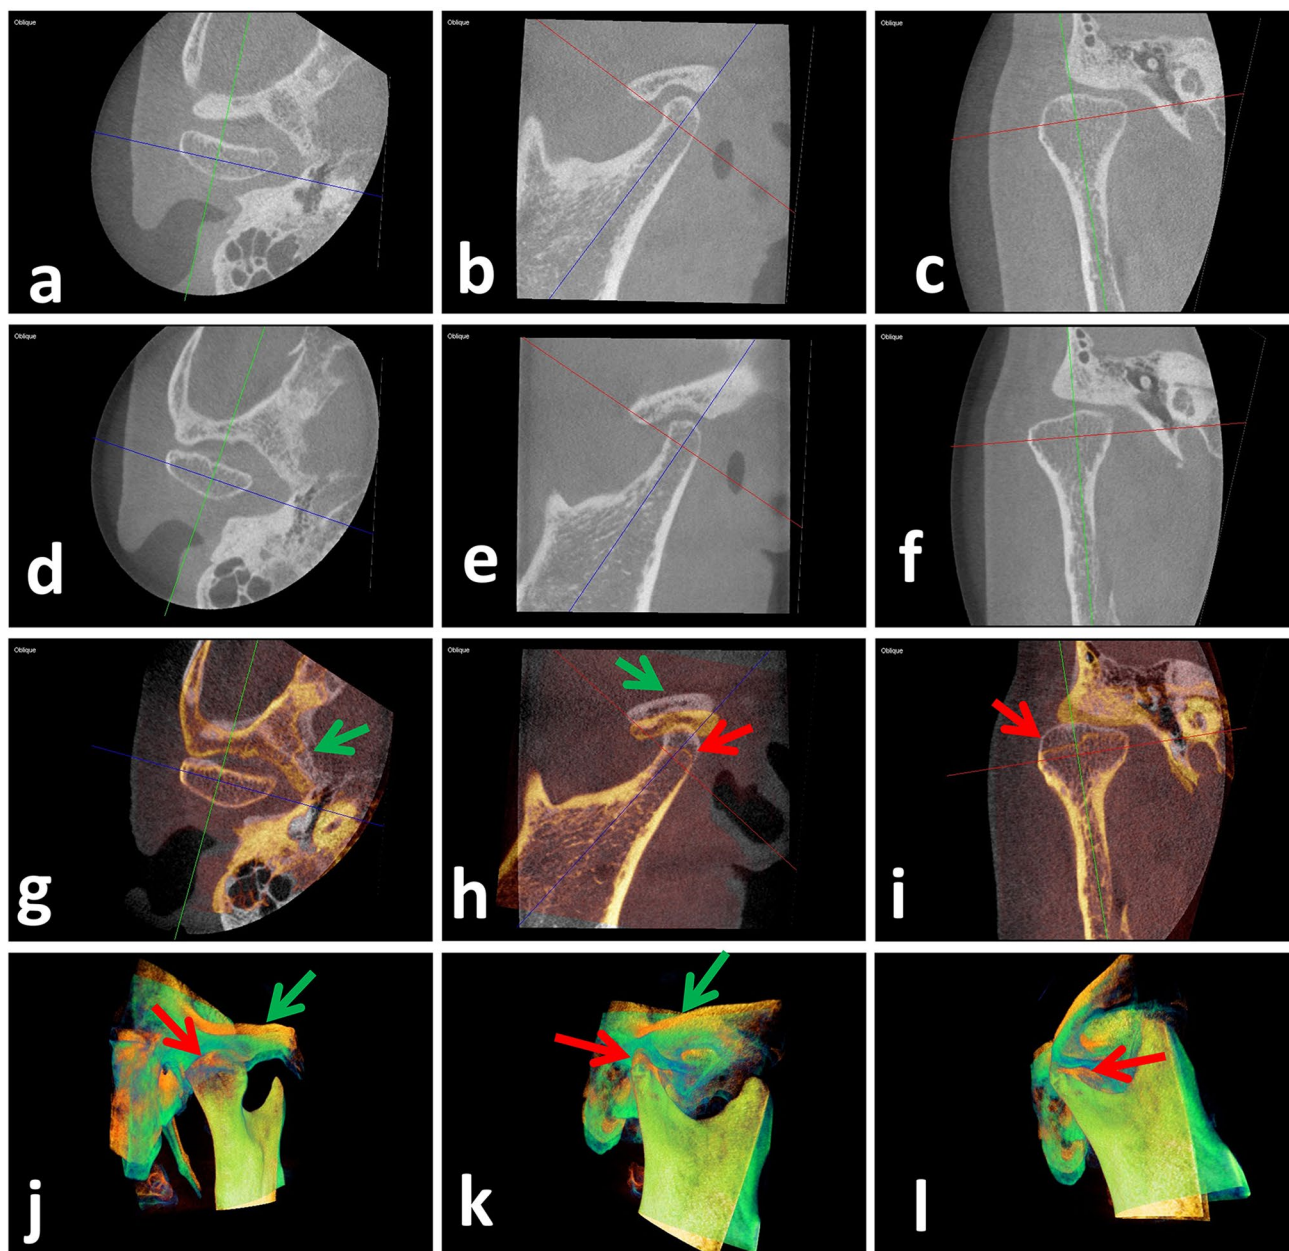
Example images for the condyle with obvious resorption. Axial (a), oblique coronal (b), and oblique sagittal (c) view of the T1 CBCT images; axial (d), oblique coronal (e), and oblique sagittal (f) view of the T2 CBCT images; axial (g), oblique coronal (h), and oblique sagittal (i) view of the fused sectional CBCT images. The gray area pointed by the red arrow indicates obvious bone resorption, and the gray area pointed by the green arrow indicates the position
